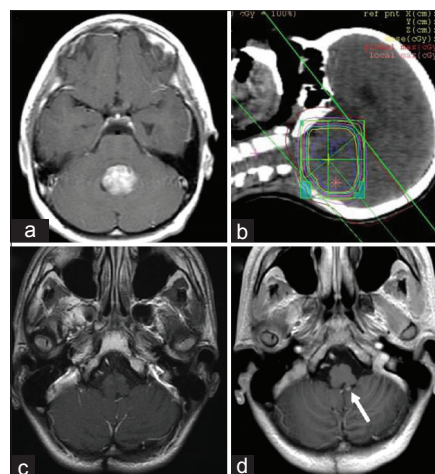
Primary tumor and follow-up magnetic resonance imaging. (a) Gross-total removal of the medulloblastoma. (b) Radiotherapy at 32.4 Gy for the posterior fossa and 23.4 Gy for the whole brain and spine; consequently, 55.8 Gy was irradiated around the tumor cavity. (c) Image obtained 7 years later showing no evident aneurysmal formation. (d) The 5-mm hyperintense nodule (arrow) on the continuous wall of the resected cavity discovered 9 years later
